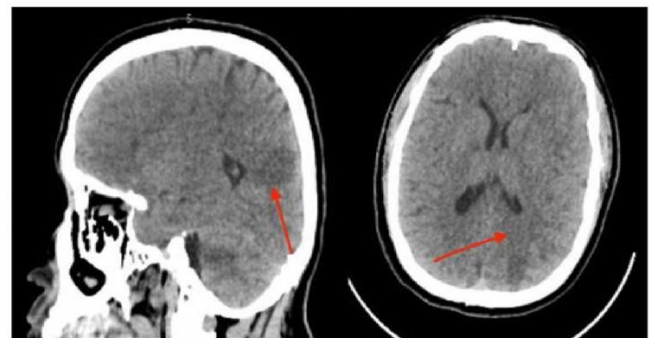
Cerebral contrast-enhanced computed tomography (CT)
